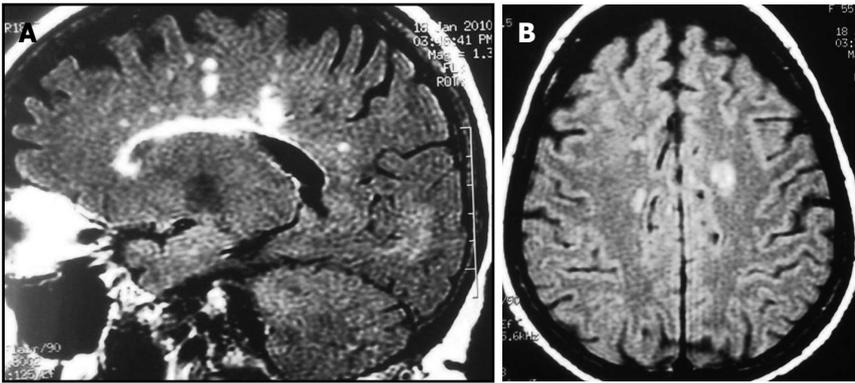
Sagittal (A) and axial (B) cranial magnetic resonance imaging scan depicting several hyperintense focal lesions in supratentorial white matter. The patient was a 45-year-old woman with relapsing-remitting multiple sclerosis and a 23-year history of ulcerative colitis.
